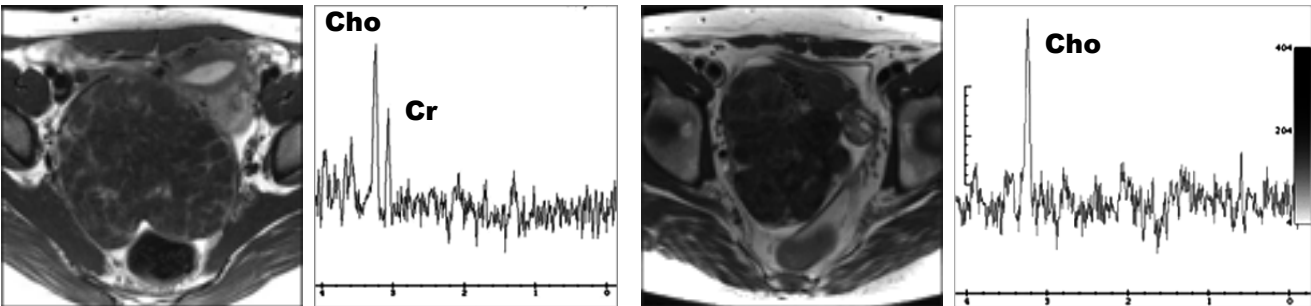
Subserosal leiomyoma shows low signal intensity on T2-weighted image, and bimodal peaks of choline and creatine on MRS.
